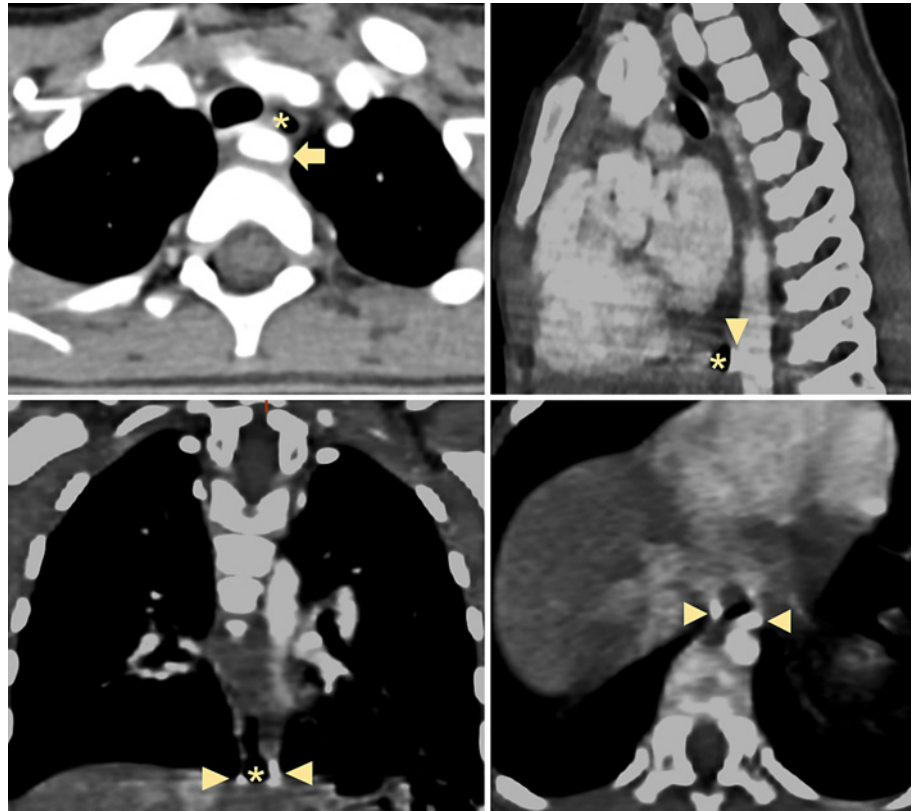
Chest CT scan shows an aberrant right subclavian artery (arrow), passing around the esophagus (asterisk), with esophageal compression. On the distal esophagus (asterisk), the exam reveals two millimetric hyperdense images (arrowheads), nonspecific, without significant stenosis.
